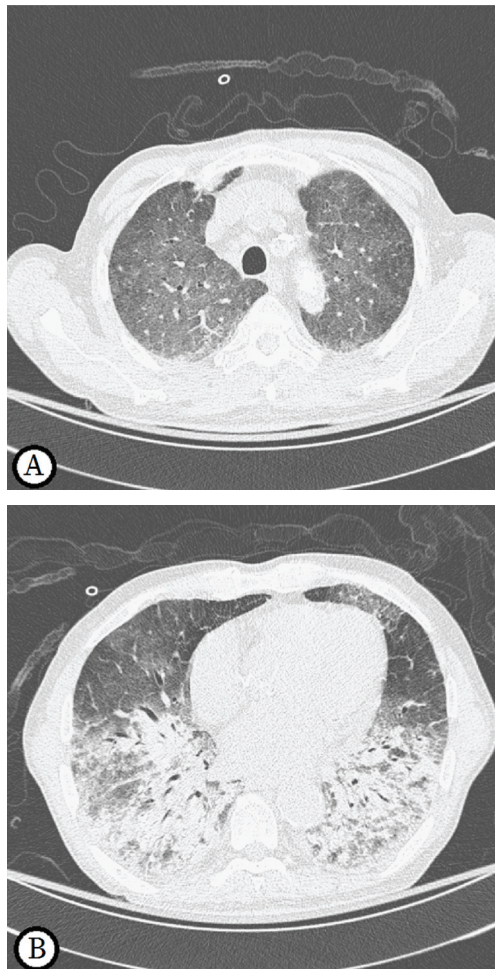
Chest CT showed mixed (A) ground-glass opacity and (B) consolidation infiltration in both lung fields.
